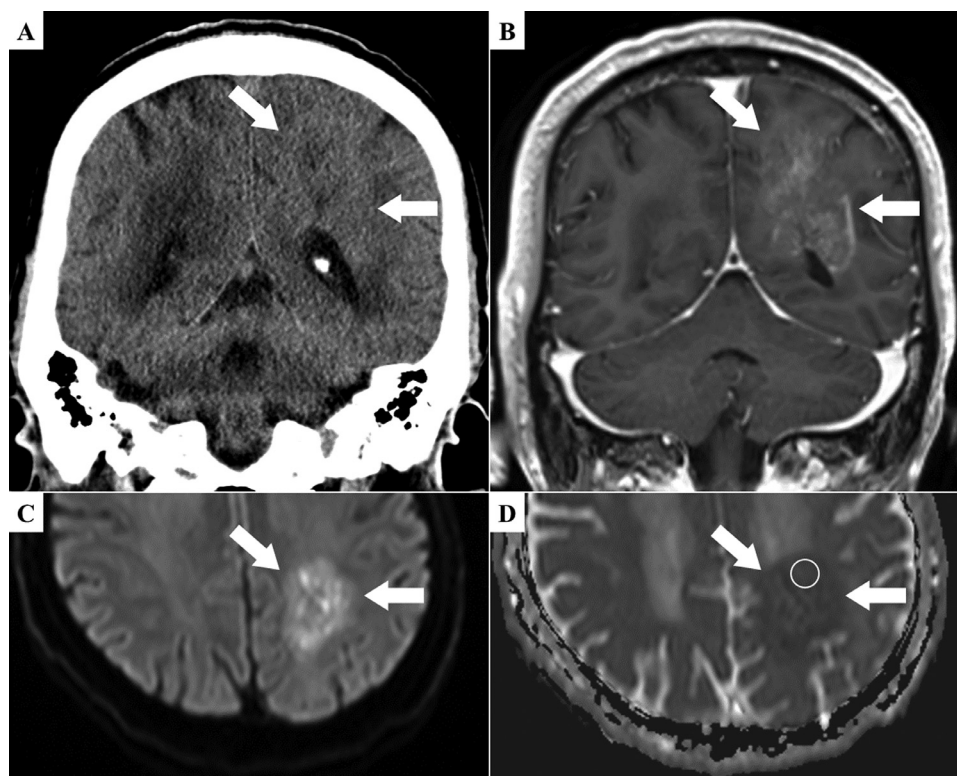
Imaging obtained after steroid administration. (A) Non-contrast-enhanced CT at 15 days after the first day of steroid treatment shows increased lesion density and reduced perifocal edema (arrows). (B) Contrast-enhanced T1-weighted MRI at 18 days after the first day of steroid treatment shows markedly reduced contrast enhancement (arrows). (C, D) DWI at 18 days after the first day of steroid treatment shows reduced diffusion capability (arrows), with an ADC of $0.716 \times 10^{-3} \text{ mm}^2/\text{s}$ (circle). The regions of markedly restricted diffusion indicate possible areas of intratumoral ischemia.
